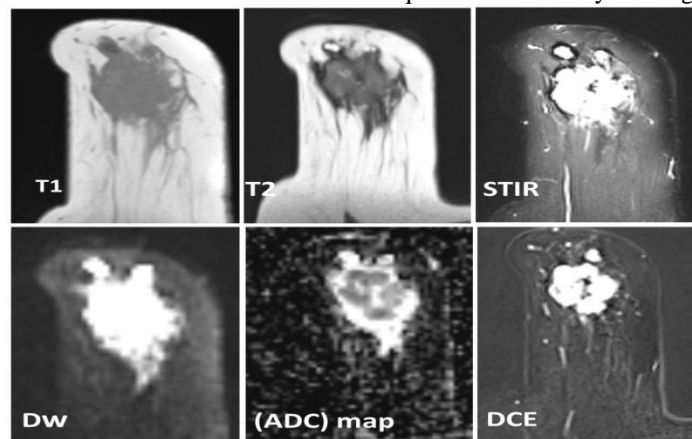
case 2: MRI of the right breast shows large mass seen opposite 12 o'clock of intermediate signal intensity on T1 and T2 weighted images, high signal intensity on STIR, DWI shows high signal intensity and low signal intensity on ADC map with ADC value of 1.196 mm²/S. MR subtraction sequence shows early heterogeneous enhancement.
